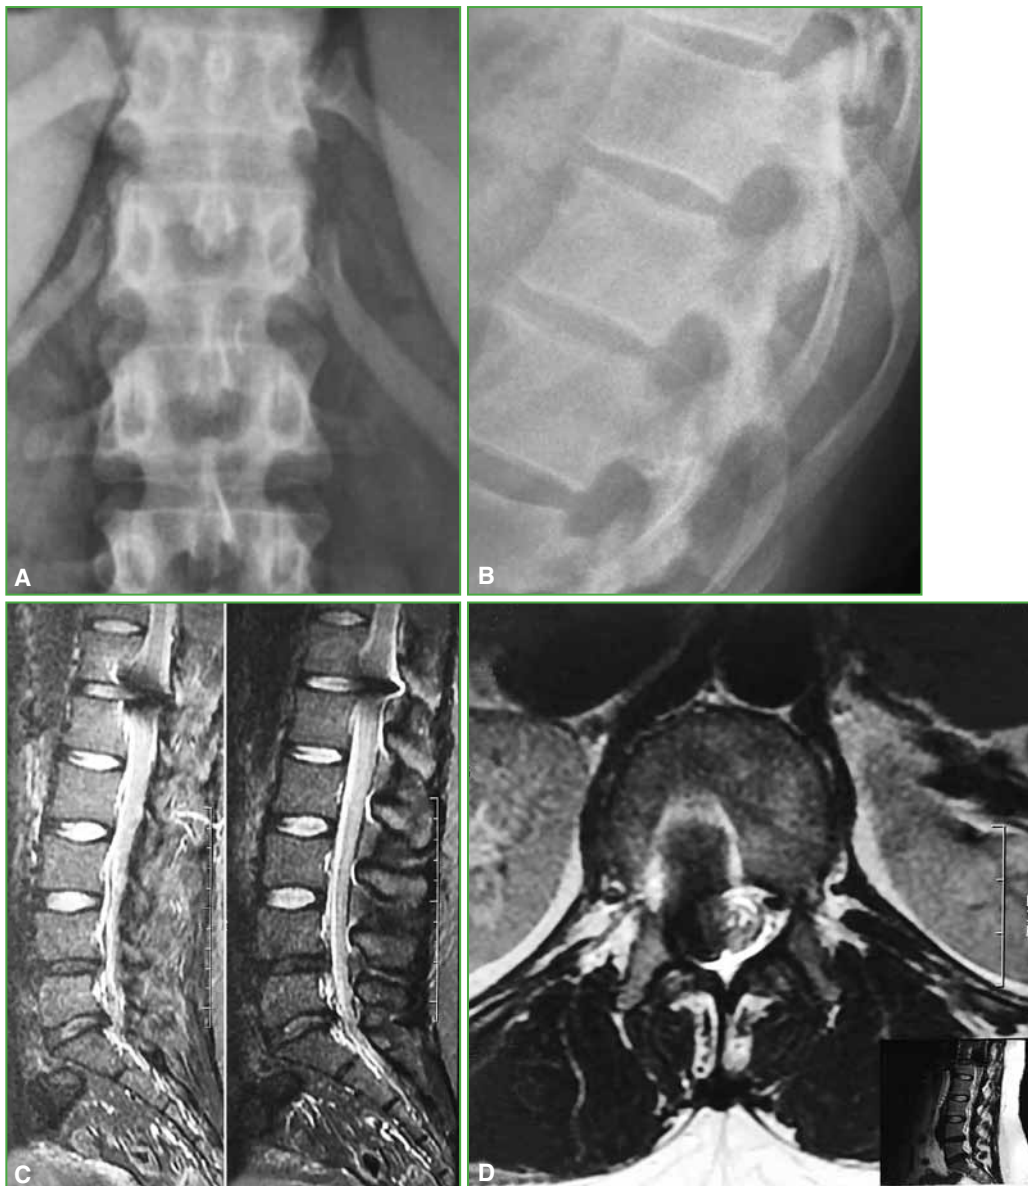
A and B. Thoracolumbar spine radiograph. An intracanal spinal needle fragment is visualized. C and D. Lumbar spine magnetic resonance, sagittal and axial planes. The artifact generated by the intracanal needle is observed.
